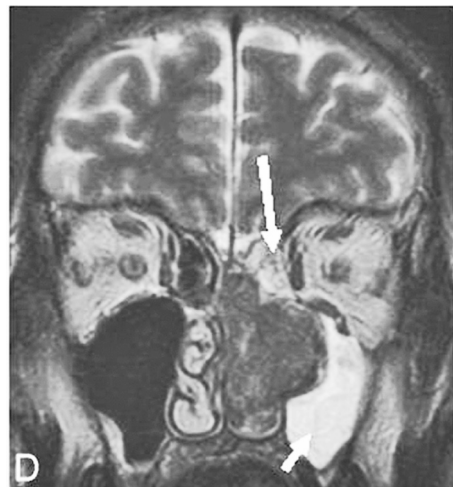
Image from Magnetic Resonance Imaging (MRI) scan in the French study verified the finding on the origin of woodworkers' nasal adenocarcinoma in olfactory cleft with retention in the squeezed ethmoidal labyrinth (pointing arrow) (Image courtesy of Georgel et al., 2009. Reproduced with permission from American Journal of Neuroradiology)
